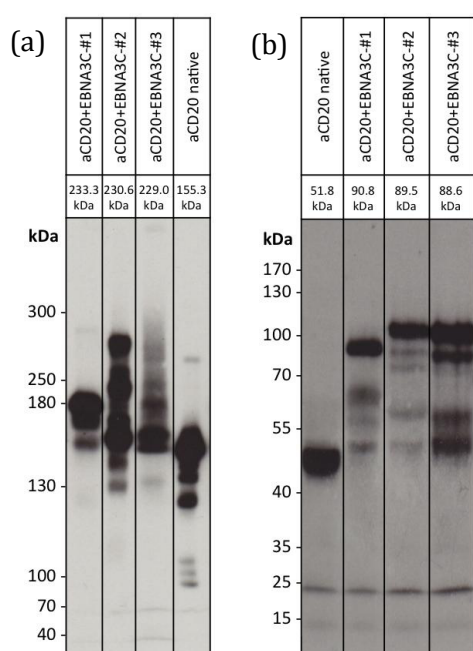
Expression profile of anti-human CD20 antibodies with and without attached EBNA3C segments analyzed by Western blot. (a) Supernatants of transfected 293 cultures were analyzed under native conditions. The SDS-PAGE was run on a 7.5 % separating gel with 2 ng of antibody loaded per lane. The chemiluminescent Western blot was exposed to an x-ray film for 5 min. Protein bands of the complete antibody and other variations of the Ig heavy and light chain complexes were detected. The expected molecular weights are given in the graph. (b) Transfected 293 cell extracts were analyzed under reduced conditions using β -mercaptoethanol. Ig heavy and light chain bands of the antibody and variations of the heavy chain were detected. The SDS-PAGE was run on a 12.5 % separating gel with 18 μL of each 293 cell extract loaded per lane. The chemiluminescent Western blot was exposed to an x-ray film for 5 min. The expected molecular weights of Ig heavy chains are
